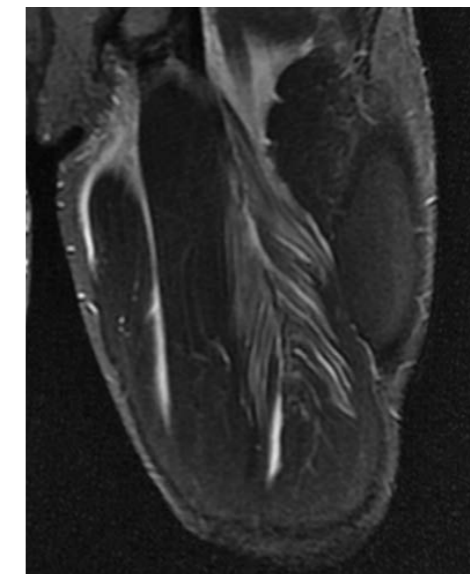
MRI Coronal STIR. Myotendinous junction strain of the long head of biceps femoris. Typical feathery pattern of oedema at the myotendinous interface characteristic of a strain. Partial myofibril disruption in this case is present, consistent with a Grade 2 injury.
